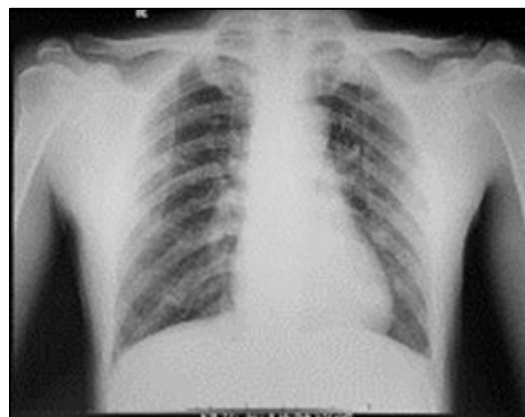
Chest X-ray with no metastasis.
